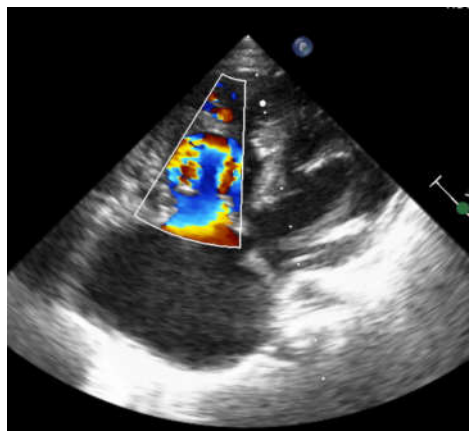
Colour Doppler showing RV obstruction.
